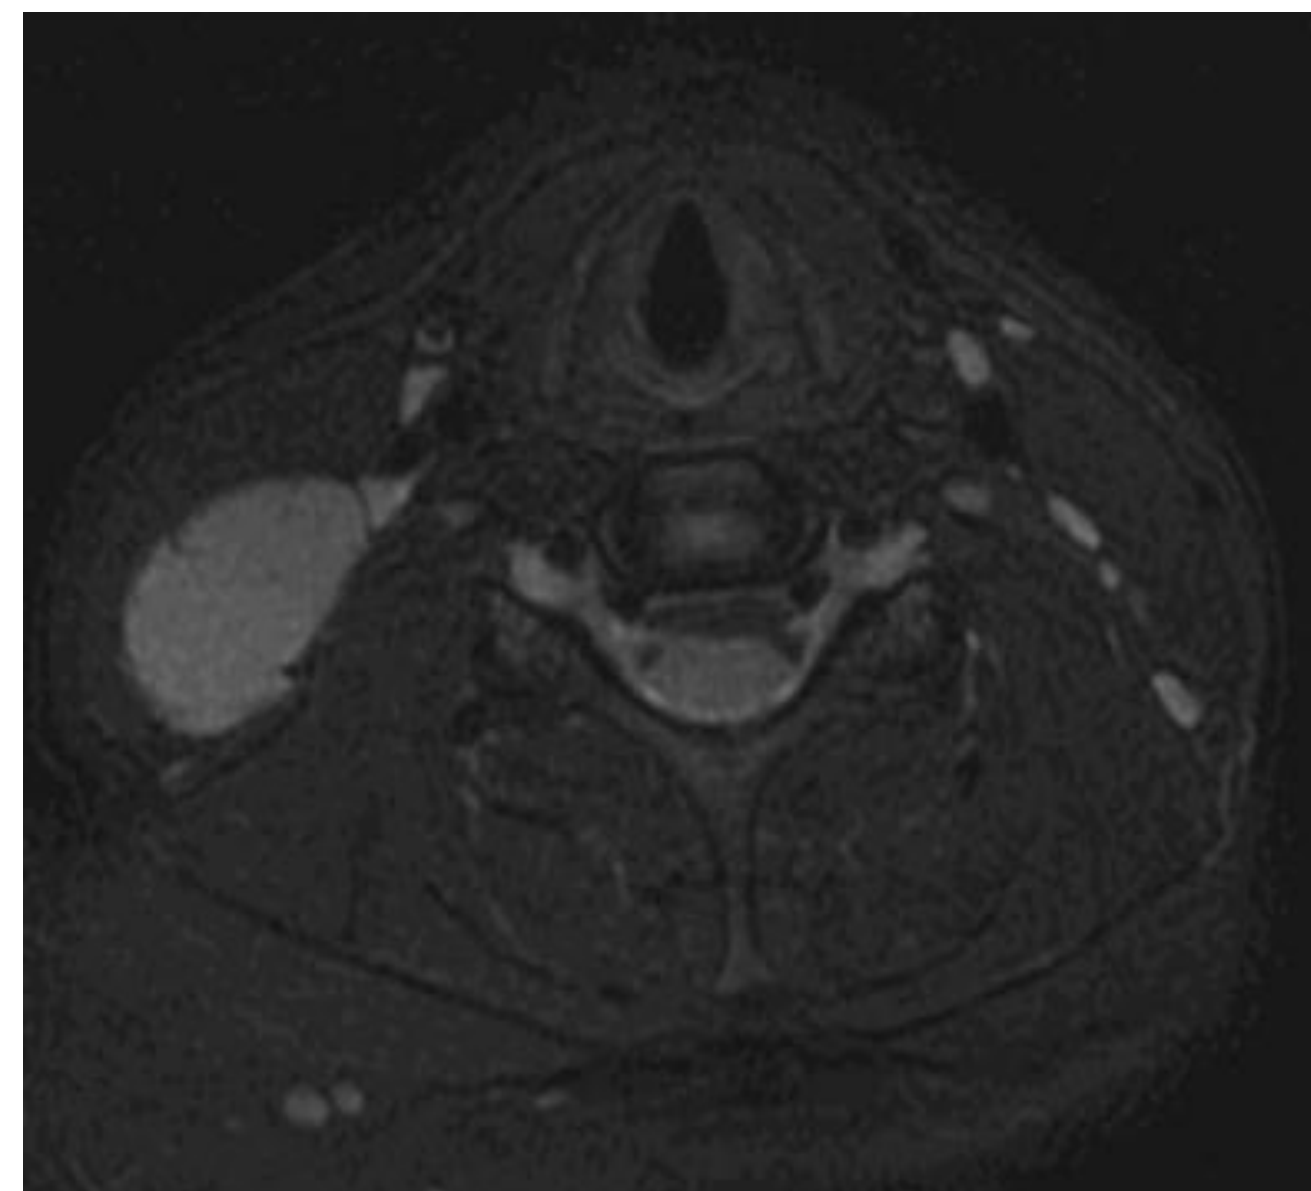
Neck magnetic resonance imaging of right-neck mass. Axial T2-weighted cut shows a hyperintense mass.
